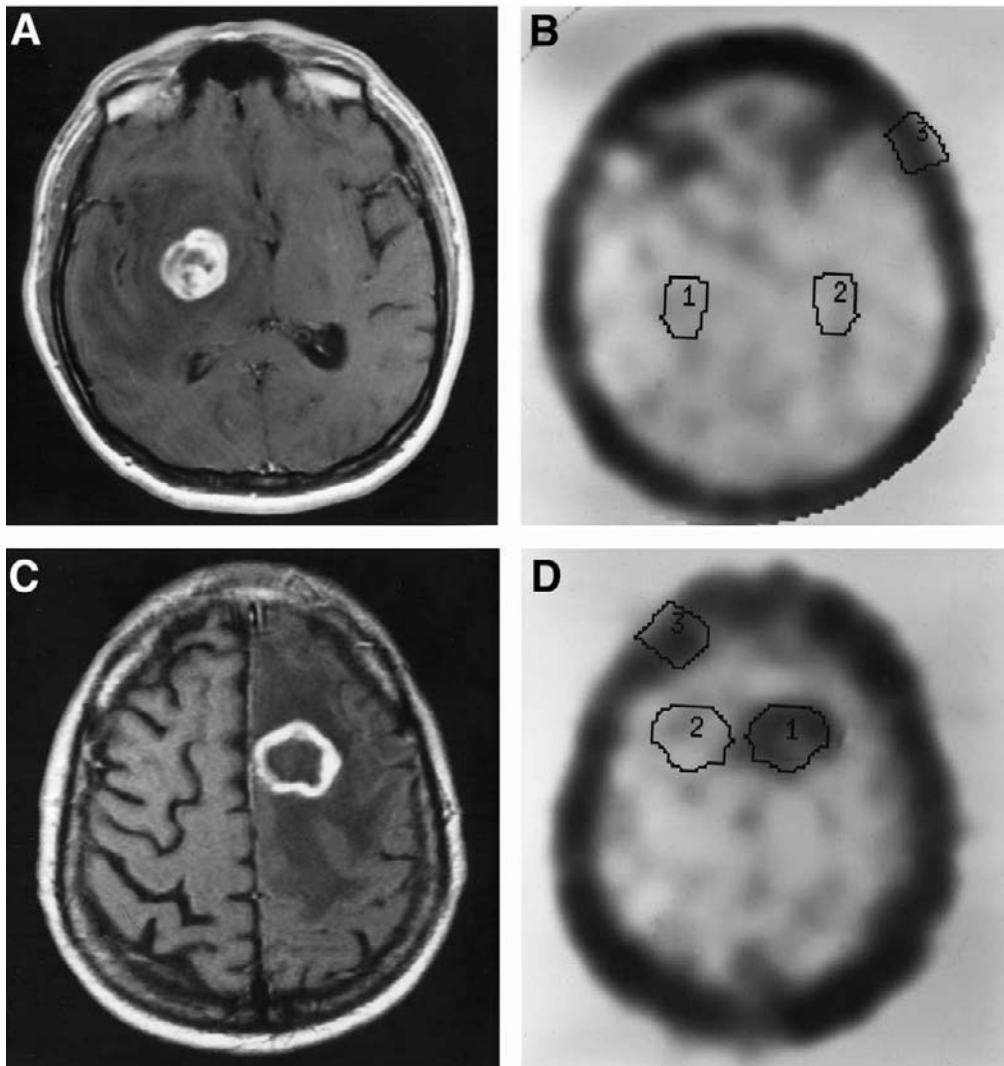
Single-photon emission CT (SPECT) thallium-201 images. *A*, Gadolinium-enhanced T1-weighted MRI of a patient who had CNS toxoplasmosis diagnosed. MRI reveals a single lesion that enhances with gadolinium. Surrounding brain edema is present. *B*, Cross-sectional SPECT thallium-201 image of the patient in panel *A* that shows lack of ^{201}Tl uptake, consistent with toxoplasmosis or another nonmalignant cause. Superimposed numbers represent regions of interest drawn around the lesion (*1*), on contralateral normal brain (*2*), and on contralateral scalp (*3*). *C*, Gadolinium-enhanced T1-weighted MRI of a patient who had CNS lymphoma diagnosed. MRI reveals single lesion that enhances with gadolinium. Surrounding brain edema is present. *D*, Cross-sectional SPECT thallium-201 image of the patient in panel *C* that shows increased ^{201}Tl uptake in region of interest, consistent with lymphoma. Superimposed numbers represent regions of interest drawn around lesion (*1*), on contralateral normal brain (*2*), and on contralateral scalp (*3*).
